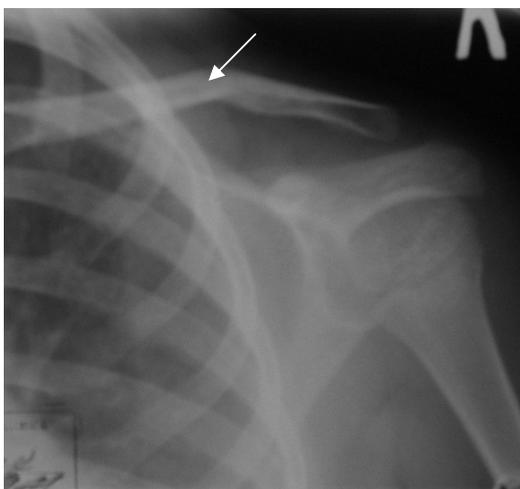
The radiograph of the humeral joint in a direct projection. Fracture of the clavicle body with fragments displacement under a corner opened downwards (arrow). The line of fracture is not detected. A healing stage. Solid fracture of the clavicle body.
